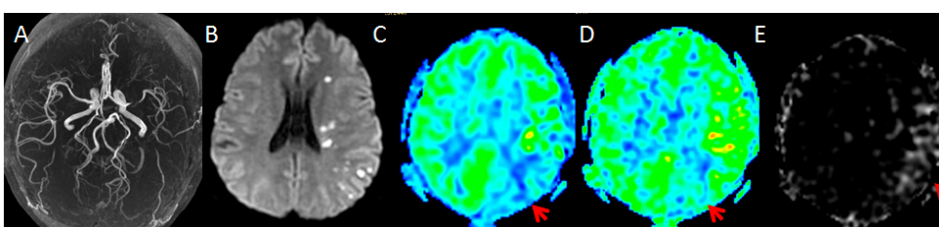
Left MCA with severe stenosis was showed on 3DTOF (A) in a 34-year-old symptomatic patient. DWI (B) showed high signal in territory of left MCA. Hypoperfusion was noted on 3D pCASL with PLD 1.5 S (C, arrow) and 2.5 S (D, arrow). High signal on subtraction image between PLD 1.5 S and 2.5 S was smaller than the former (E, arrow).
